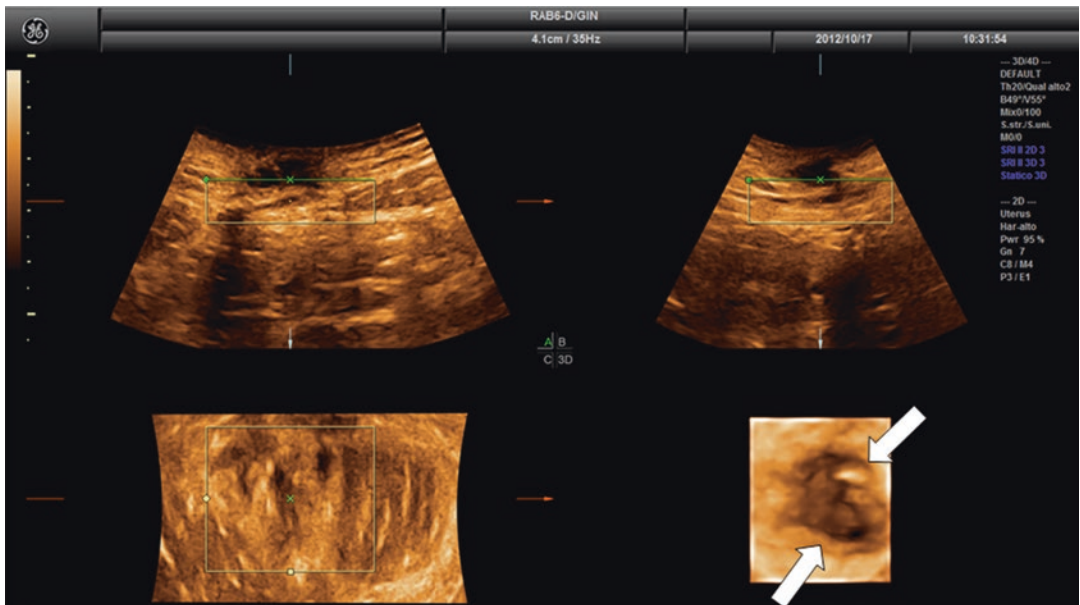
Three-dimensional ultrasonographic appearance of Villar's nodule (straight arrows) in a 20-year-old woman without previous abdominal surgery
